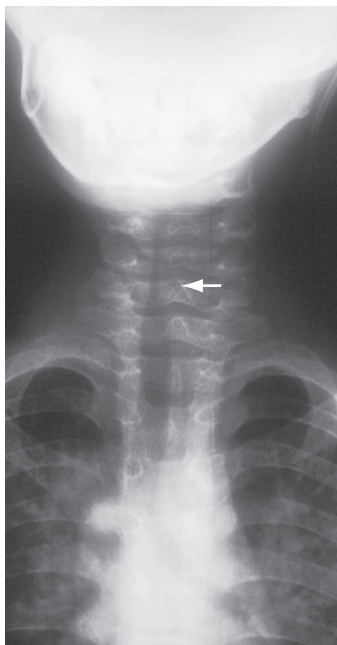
Anteroposterior radiograph of the neck region of child with croup. Note the steeple sign (white arrow). (From Wetmore RF. Pediatric otolaryngology: the requisites in pediatrics. 1st ed. Philadelphia: Mosby, 2007, Fig. 11-1.)
